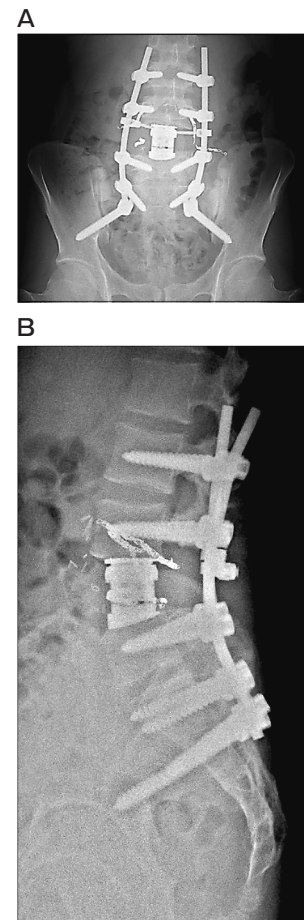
Postoperative radiograph revealing posterior instrumentation with anterior reconstruction using an expandable cage (A, B).
